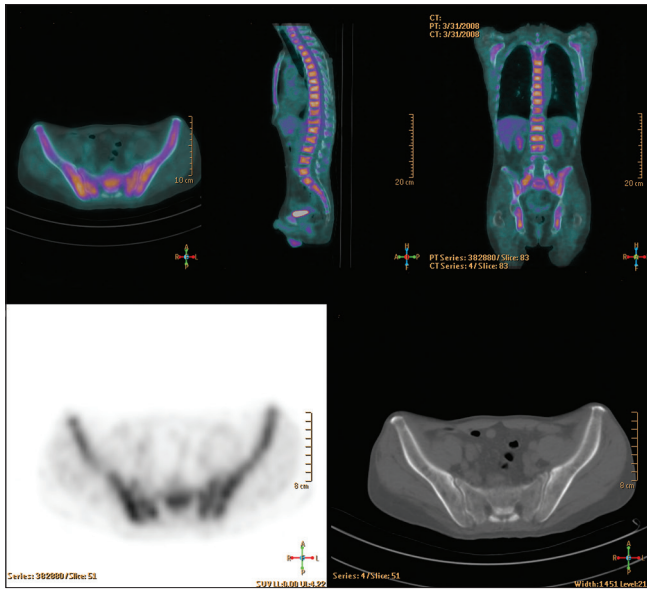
A 73-year-old man presenting with elevated CEA of 46 ng/ml. Fusion PET/CT images show diffuse homogenous hypermetabolic activity along the entire axial skeleton. No definite destructive lesion was identified on CT. Findings were interpreted as marrow hyperplasia due to chronic anemia. However, subsequent blood test revealed hyperparaproteinemia and bone marrow biopsy revealed plasma cell myeloma
